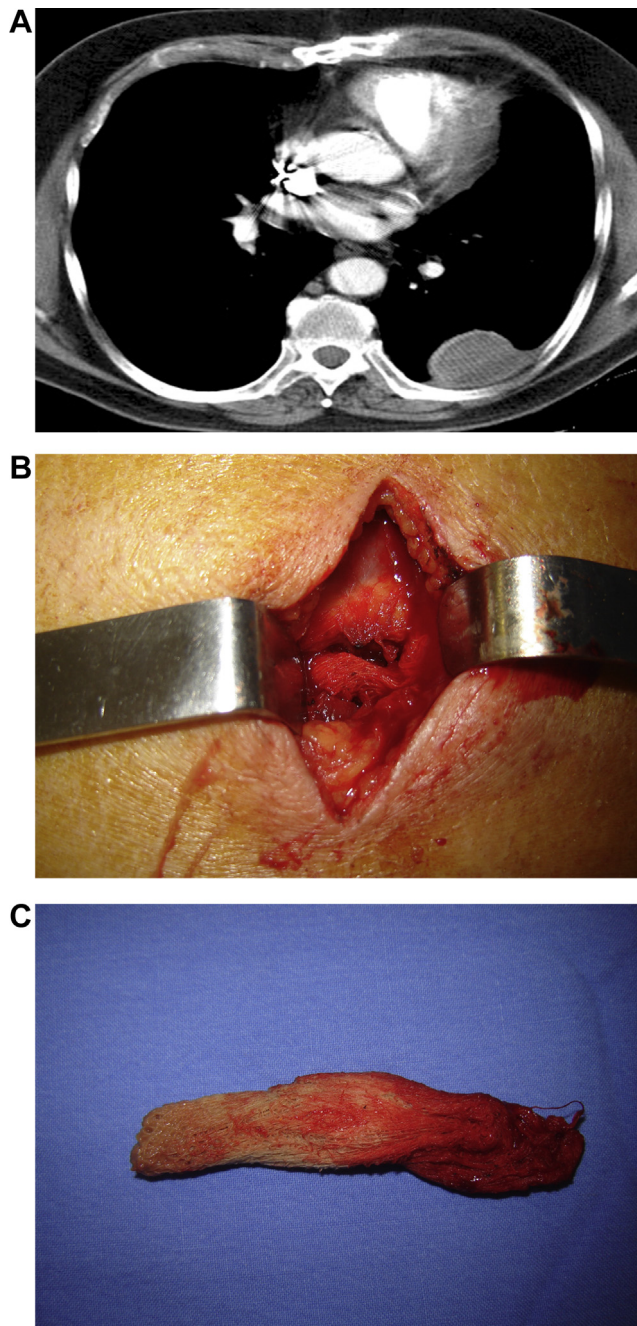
A 54-year-old woman with a thoracic textiloma. A chest computed tomography image obtained with the mediastinal window setting (A) reveals a well-defined, hypodense pleural mass in the left hemithorax with a hyperdense peripheral rim. (B,C) A foreign textile body (gauze) was surgically excised from the pleural cavity (Reprinted with permission from Nobre LF, Marchiori E, May F, Carrão AD Jr., Zanetti G, Machado DM. Thoracic textilomas after myocardial revascularisation: typical CT findings. *Br J Radiol.* 2010; 83 (985):4–7).
